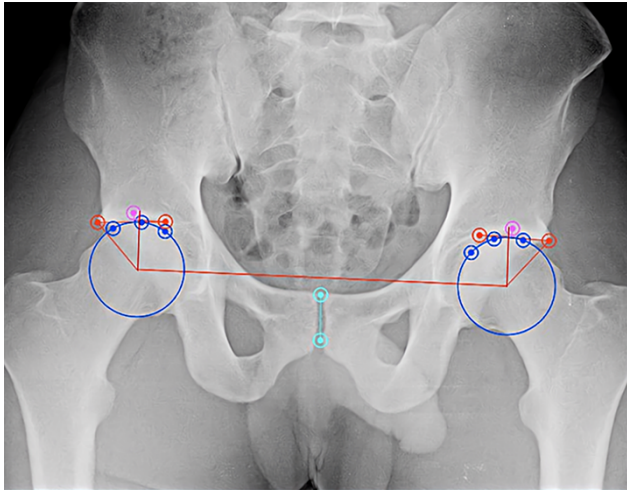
AP pelvis radiograph with OsiriX measurements for lateral center-edge angle (LCEA, red).
